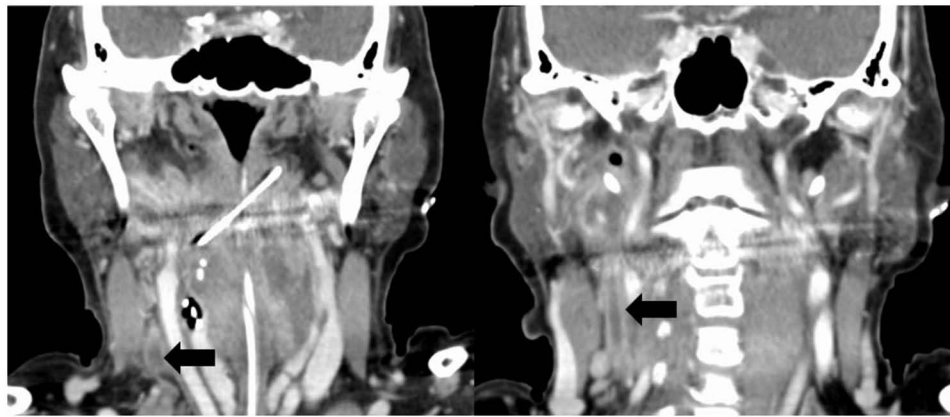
Enhanced computed tomography of the neck. Black arrow indicates right internal jugular vein thrombosis.
